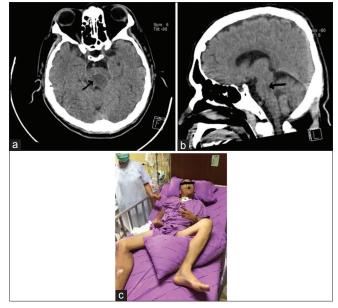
(a and b) Computed tomography brain scan showed resolved hematoma, residual area of cavity-like lesion at left tegmentum (arrow), (c) patient can count fingers
